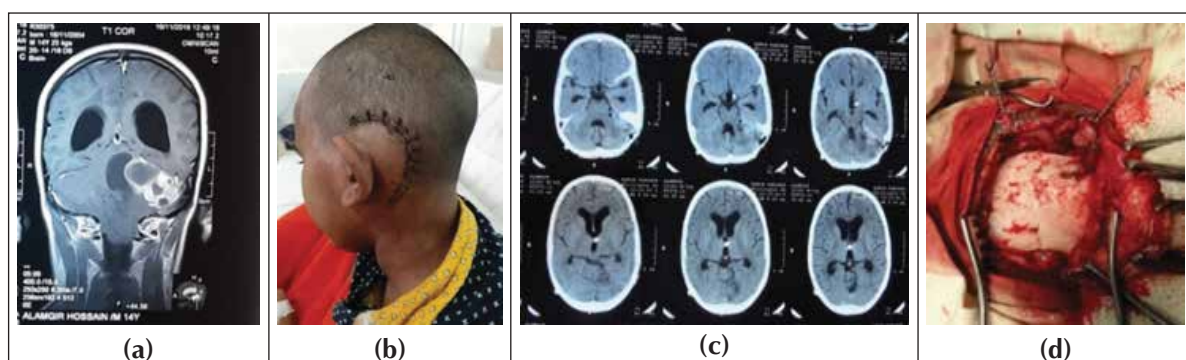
Coronal contrast image of a 14-year-old boy showing a) Posterior fossa tumor (in left CP angle location), b) incision used in retro sigmoid approach c) Post op CT scan d) Exposure of asterion.
